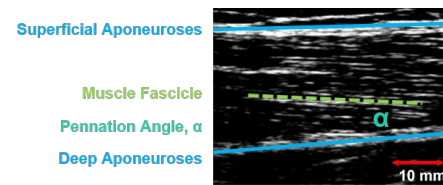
Representative region of interest from raw ultrasound image of rectus femoris with kinematic muscle contraction features labeled.
